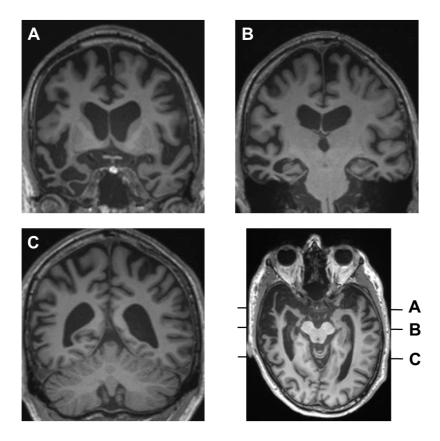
Representative coronal and axial sections of the patient's T1-weighted structural brain MRI. The right hemisphere is projected on the left side of each image. There is marked, relatively selective atrophy involving the right anterior temporal lobe, most severe in temporal polar, inferior temporal, fusiform and entorhinal cortices, amygdala and anterior hippocampus, with much less marked, mirroring atrophy of the left anterior temporal lobe and more diffuse background cerebral atrophy. Coronal sections at the level of the temporal poles (A), mid hippocampi (B) and temporoparietal junctions (C) (see axial reference section, bottom right) show the striking gradient of atrophy within the right temporal lobe, with severe involvement anteriorly and relative sparing of more posterior areas.
